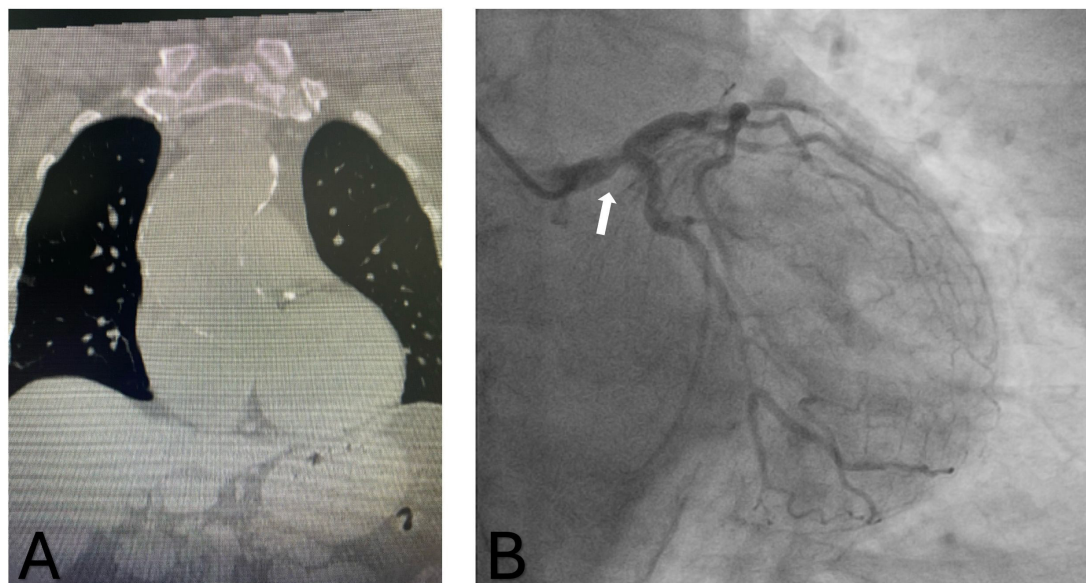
(A) Preoperative computed tomography scan showing ascending aortic aneurysm with porcelain aorta. (B) Coronary angiogram with main trunk stenosis (arrow).
